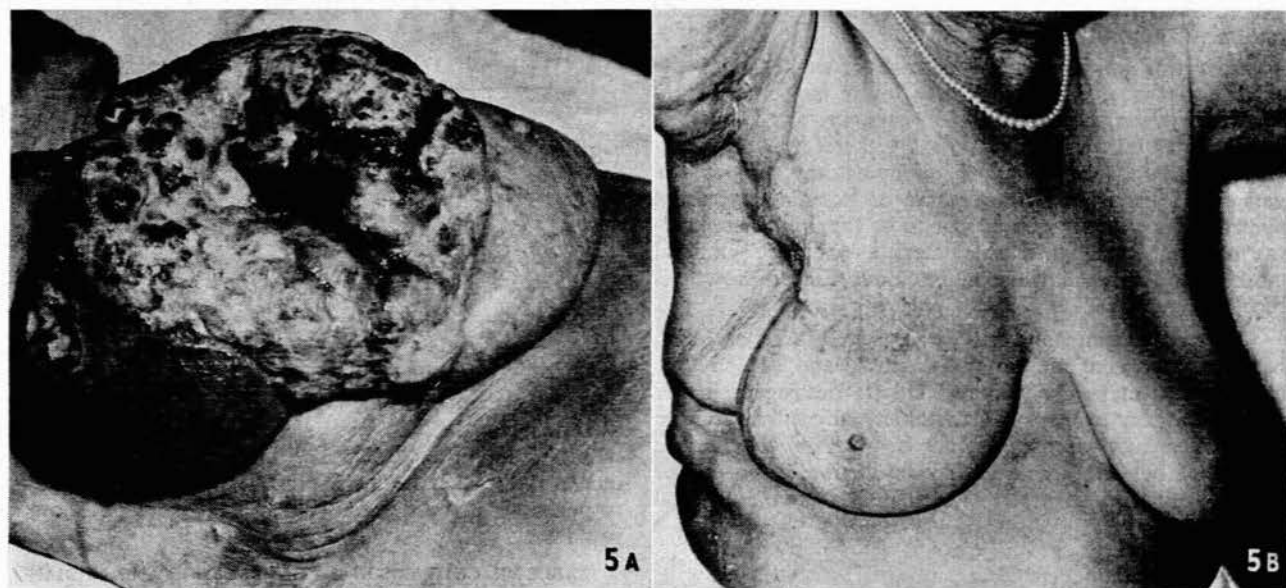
Patient with extensive ulcerating growth of the breast. A. The growth before deep X-ray and oestrogen therapy. B. The remarkably healed breast lesion 5 years later.
